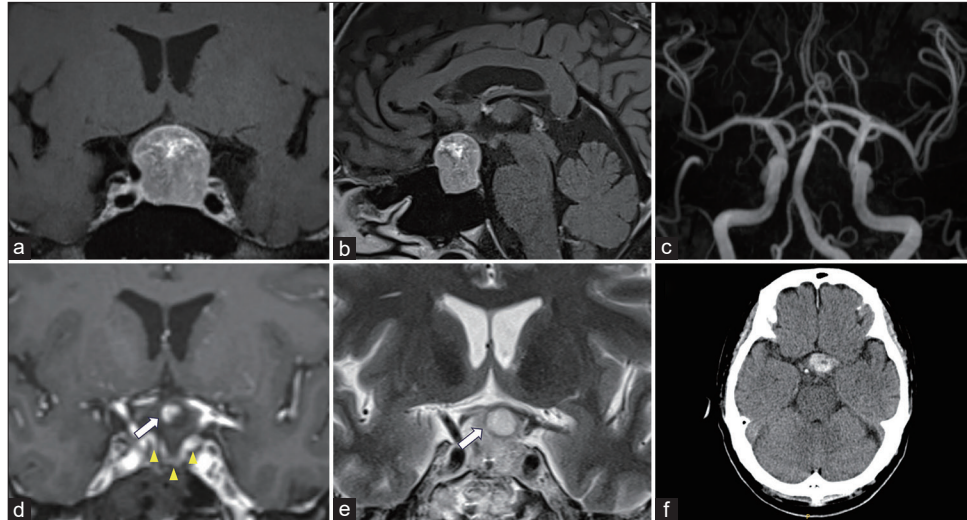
(a and b) Preoperative MRI showing a sellar mass with upper extension. (c) Preoperative MRA showed no aneurysm or vascular abnormalities around the tumor. (d) Intraoperative contrast-enhanced T1WI shows a small spot sign (white arrow), indicating acute hemorrhage between the optic chiasm and diaphragm sellae (arrowhead), and (e) T2WI showing the extent of hemorrhage (white arrow) around the spot indicated in (d). (f) Postoperative CT scan showed no expansion of hemorrhage. MRI: Magnetic resonance imaging, MRA: Magnetic resonance angiography, CT: Computed tomography, T1WI: T1-weighted imaging, T2WI: T2-weighted imaging.
